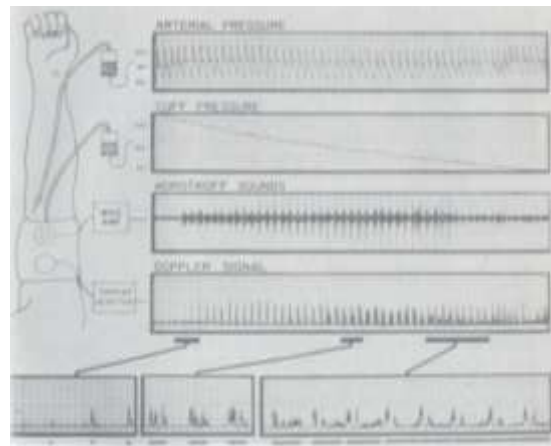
Measurement of pressure using the cuff compared with Doppler³
